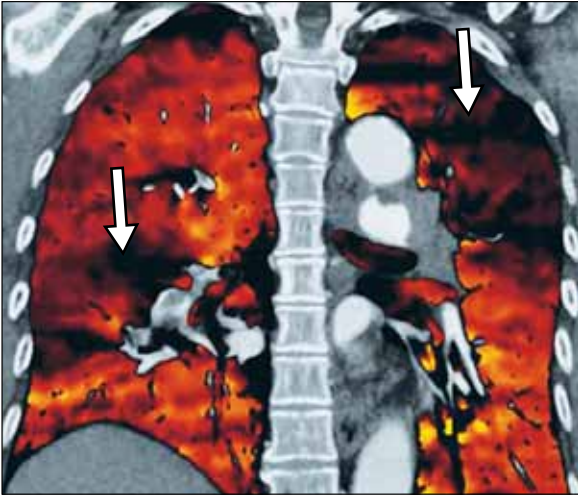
Coronal CT vascular iodine distribution map of a 31-year-old woman who presented with right calf pain and dry cough. Dark wedge-shaped perfusion defects (arrows) in the right lower and left upper lungs, typical of bilateral pulmonary embolism, are seen.
